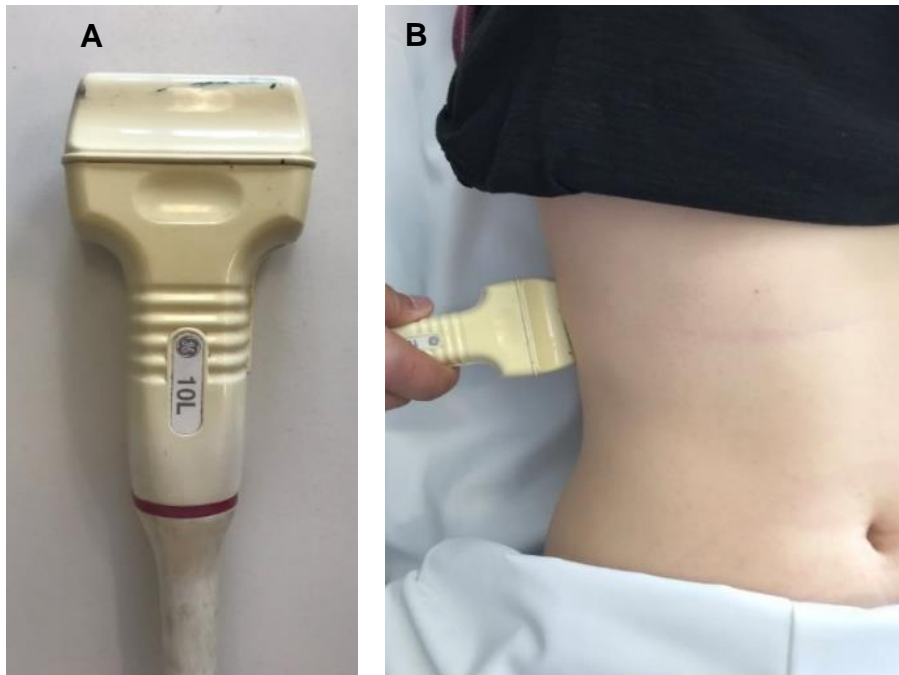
A) Linear, high-frequency ultrasound transducer used for intercostal ultrasonography. B) The transducer was positioned on the 8-10<sup>th</sup> intercostal space to image costal diaphragm thickness and thickening at the zone of apposition.
